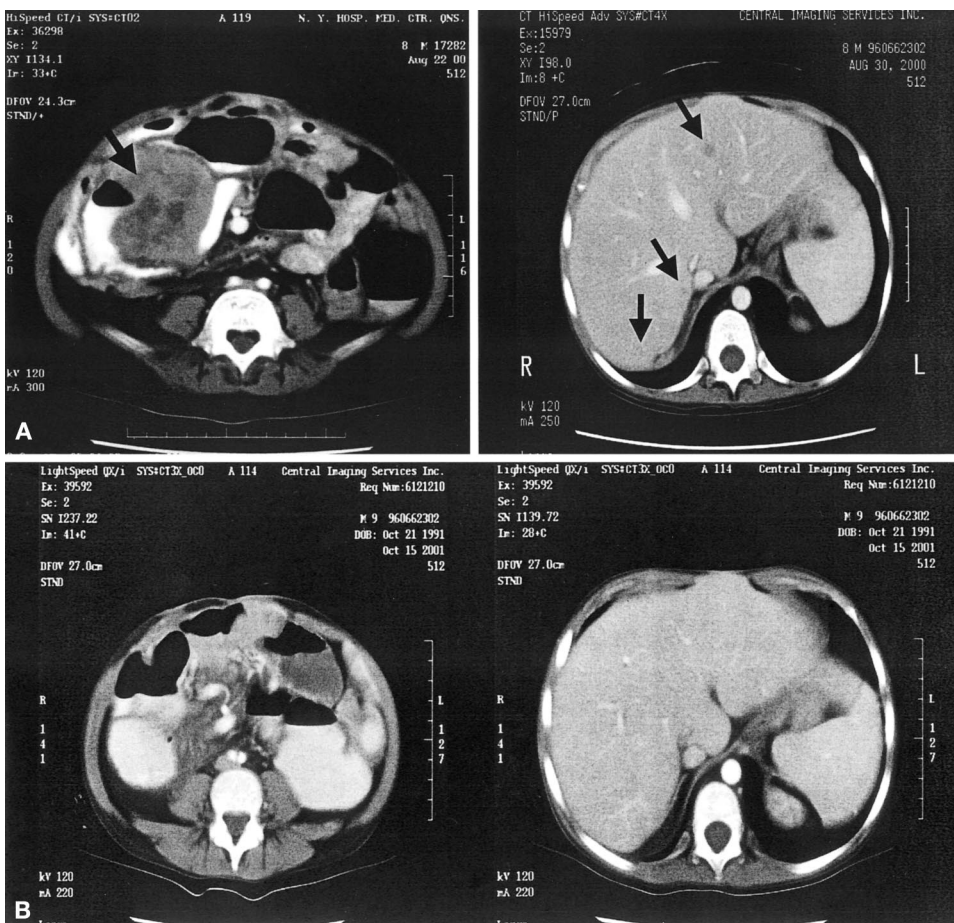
Abdominal computed tomographic scan obtained (A) at the time of diagnosis with a large mesenteric mass (*left*) and multiple hepatic lesions (*Right*) and (B) 14 months later, with no evidence of local recurrence and complete resolution of the hepatic metastatic lesions.
